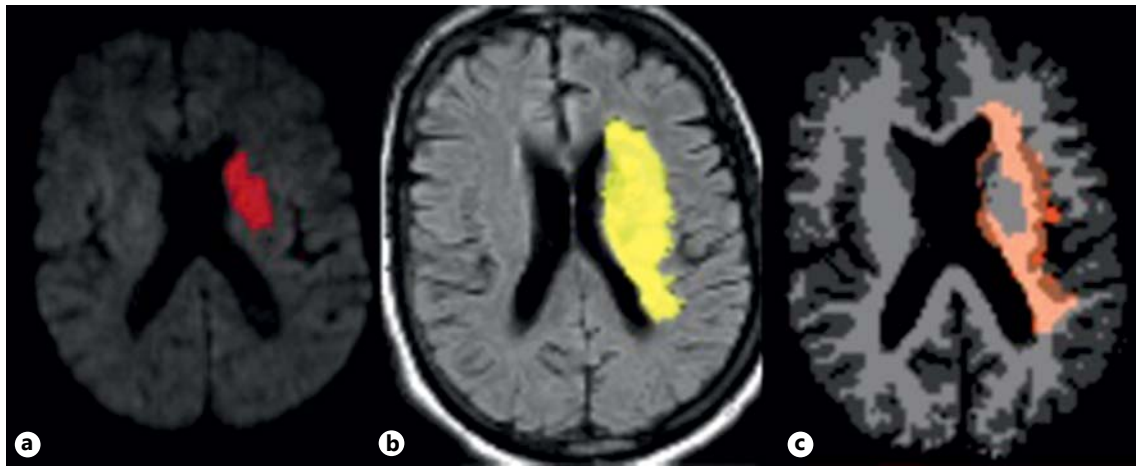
Example of lesion growth. Mask of the initial DWI lesion (a), final FLAIR lesion (b) and the lesion growth compartment (c, DWI mask subtracted from the FLAIR mask) superimposed on GM/WM segmentation maps after co-registration, showing that the extension of the ischemic lesion predominates in the WM.
